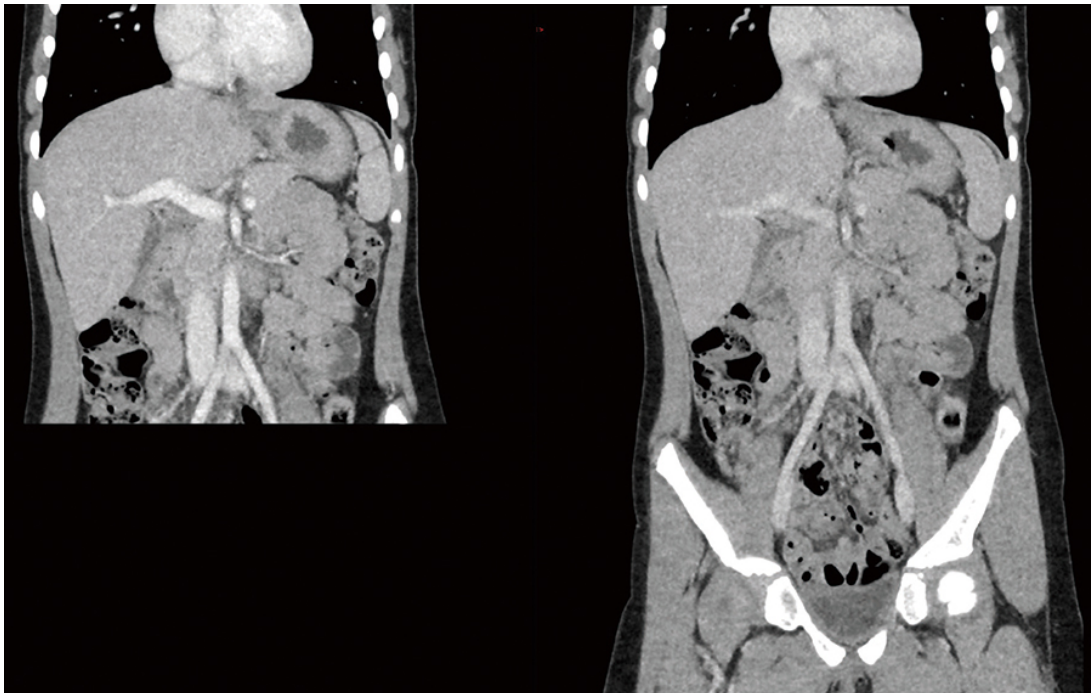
Dual-phase CT performed on a 7-year-old patient with suspected pancreatic trauma. Left: Coronal image from an arterial phase acquisition of the abdomen reconstructed with AiCE (0.3 mSv). Right: Coronal image from a portal venous phase acquisition of the abdomen and pelvis reconstructed with AiCE (0.5 mSv).
